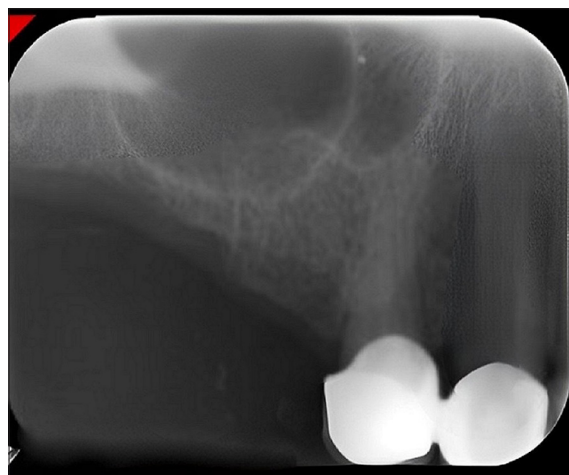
Periapical radiograph of 15 showing residual bone height of 6 mm, below the maxillary sinus.
